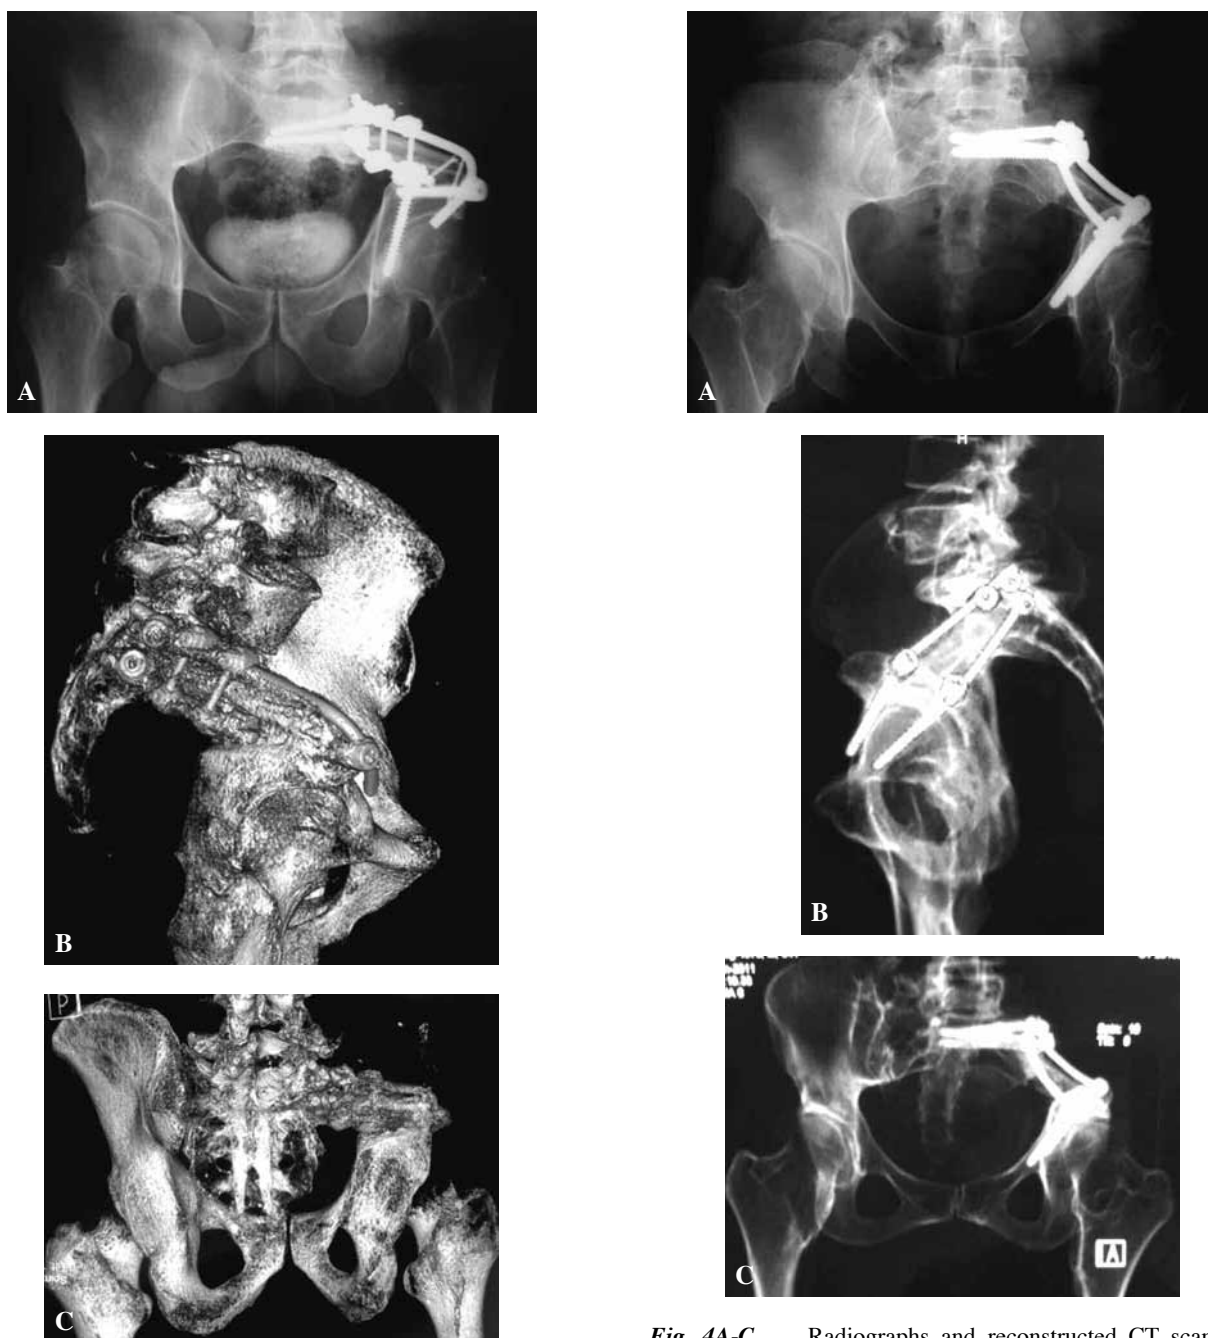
Radiographs and 3D CT scans of case 1, 3 years after type-1S pelvic resection.
